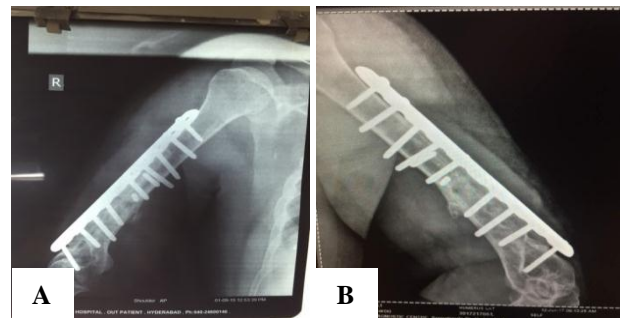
(A-C): Post operative x-rays taken 8 months and 18 months after the ORIF with LCP with autologous on lay fibular bone grafting showing bony union in both the xrays. Good range of motions was achieved.
